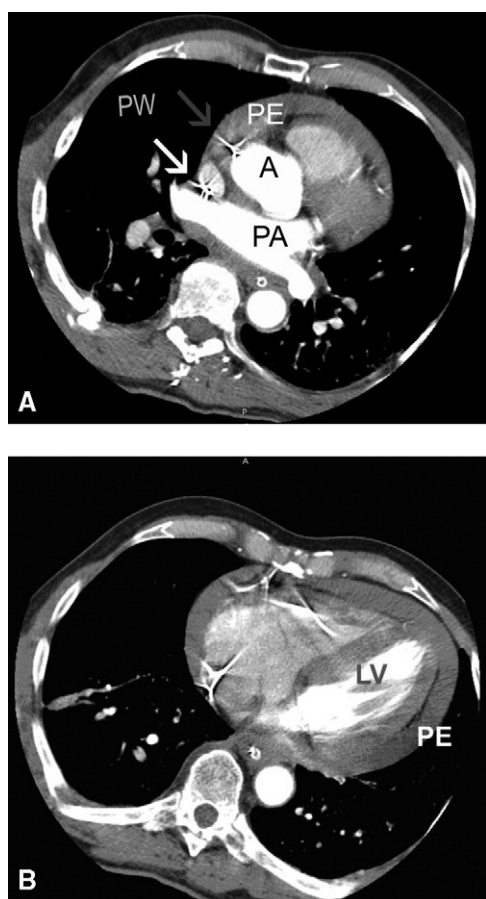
A, CT scan at arrival revealed pericardial effusion (PE) of 1.5 cm around the ascending aorta (A). Pacemaker wire (PW) is visible in the superior vena cava (white arrow) and in the right atrium (gray arrow). PA, Pulmonary artery. B, PE around the left ventricle (LV).
